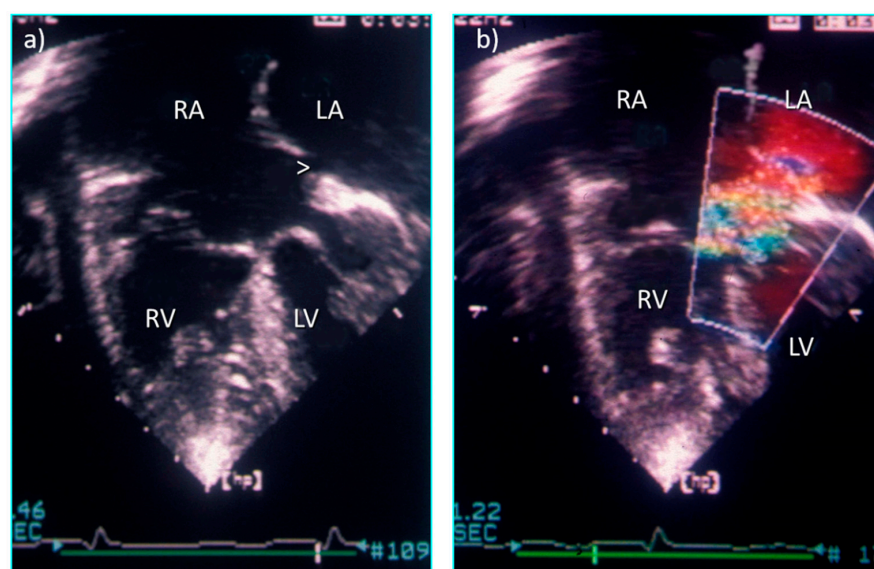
Four chamber echocardiographic sections from a heart with double outlet right atrium and restrictive primum defect (ASD) (a) without colour flow Doppler and (b) with turbulence across the restrictive ASD.
